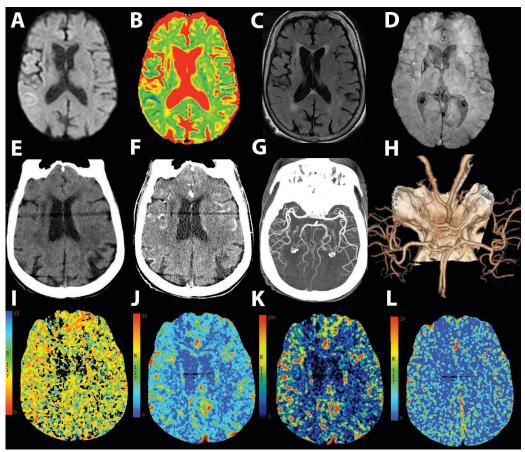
Case #2. Neuroimaging in 24 h. A-D. Magnetic-resonance imaging (MRI): A. Diffusion weighted imaging (DWI). B. The apparent diffusion coefficient (ADC) map. C. Fluid-attenuated inversion recovery (FLAIR). D. Susceptibility-weighted angiography (SWAN). E-L. Computed tomography (CT) scans: E. Non-contrast CT. F. CT-angiography source images (CTASI). G. Maximal intensity projection (CT-angiography). H. Volume rendering (CT-angiography). I-L. CT-perfusion study: I. The mean transit time (MTT) map. J. The cerebral blood volume (CBV) map. K. The cerebral blood flow (CBF) map. L. The permeability-surface area product (PS) maps.
